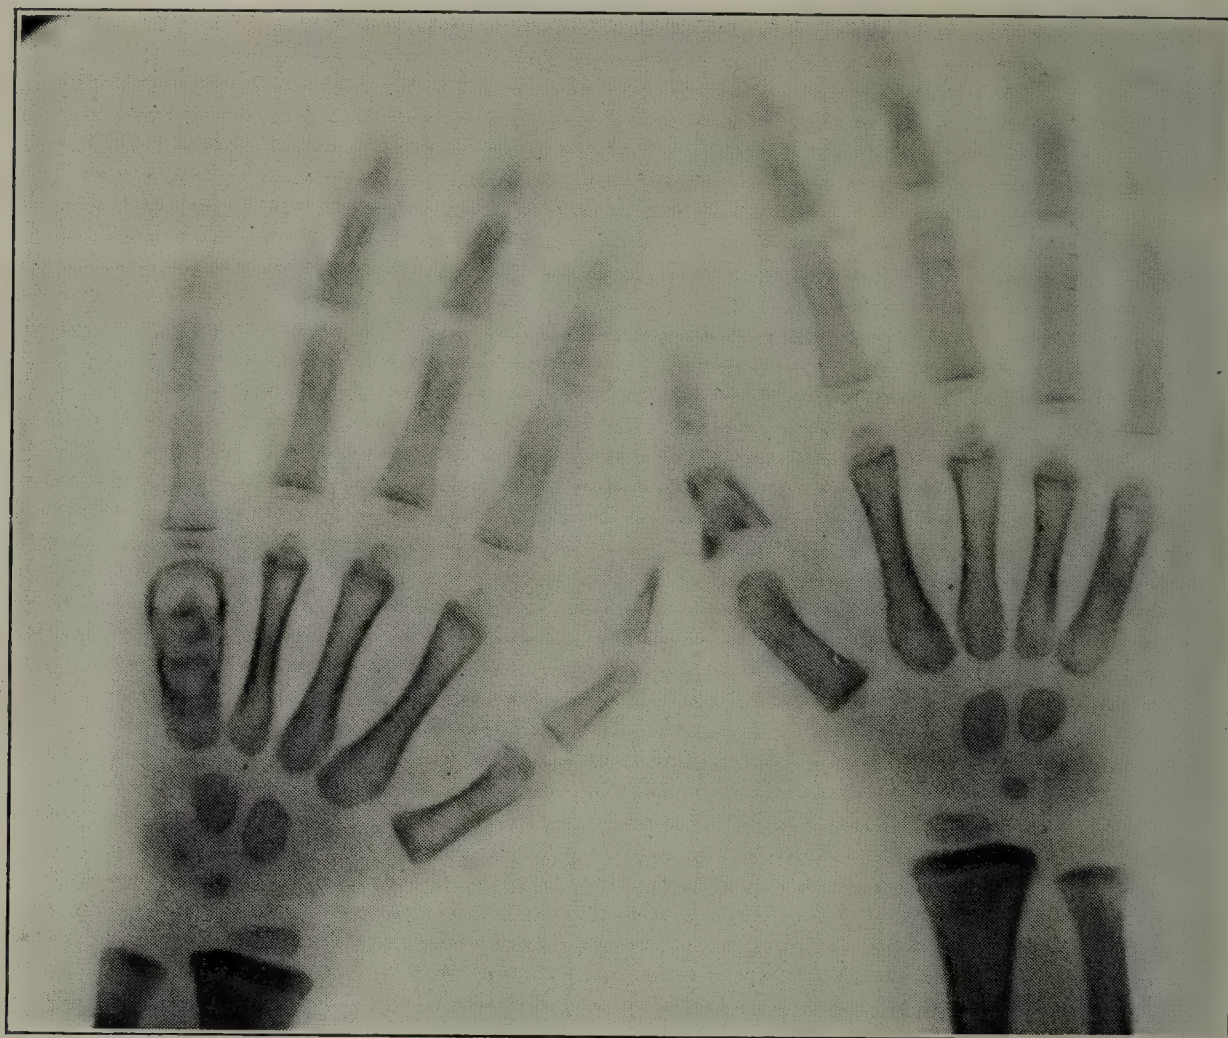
ROENTGENOGRAM IN TUBERCULOUS OSTEOMYELITIS.
